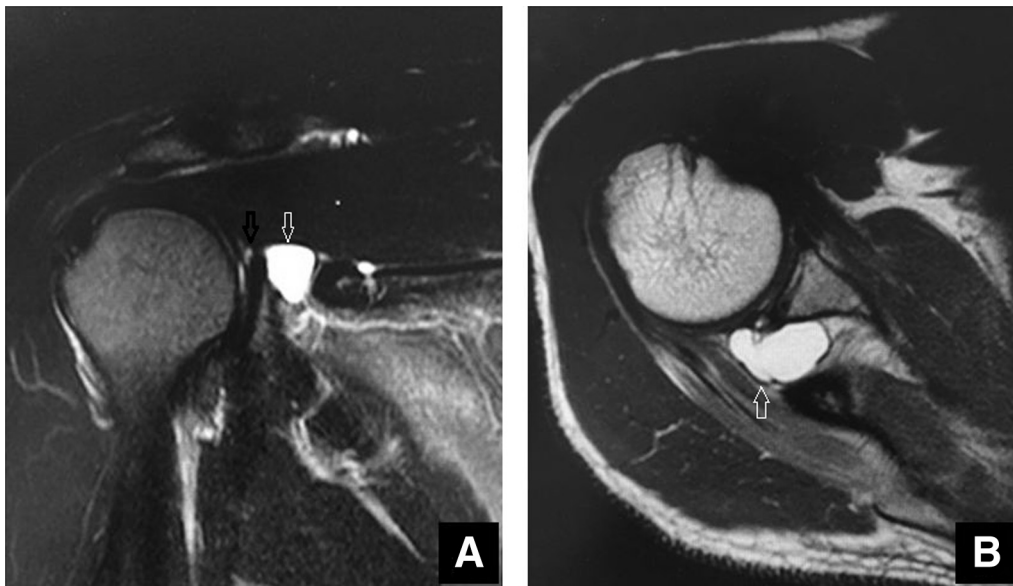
(A) Coronal magnetic resonance imaging (MRI) scan of the right shoulder demonstrates type II SLAP lesion (black arrow) and spinoglenoid notch cyst (white arrow). (B) Axial MRI scan demonstrates large lobulated cystic lesion at spinoglenoid notch causing suprascapular nerve compression (white arrow).
